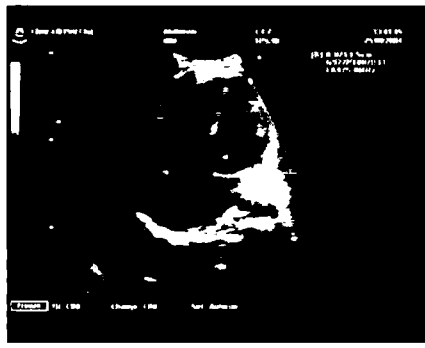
Apical 4C scan in a patient with DORV and canal AV complet.
